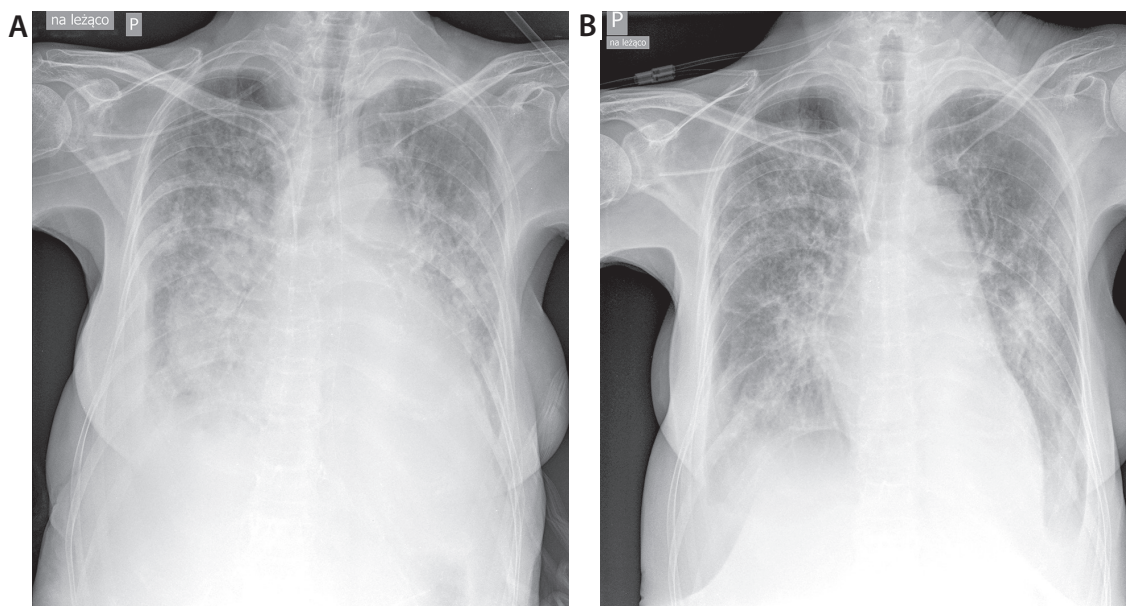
A lung X-ray on hospitalization day 2 (A) and 4 (B)
